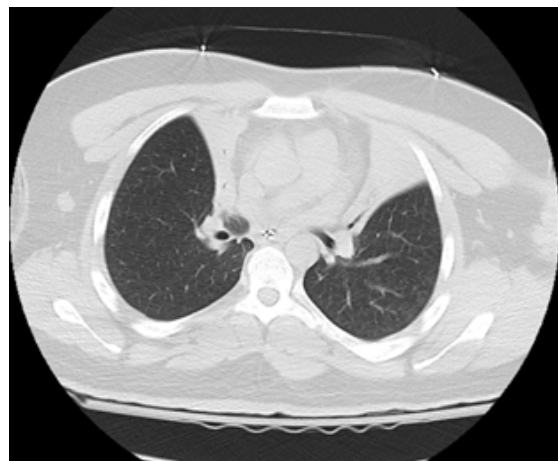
CT scan of bilateral upper lobe collapse.
